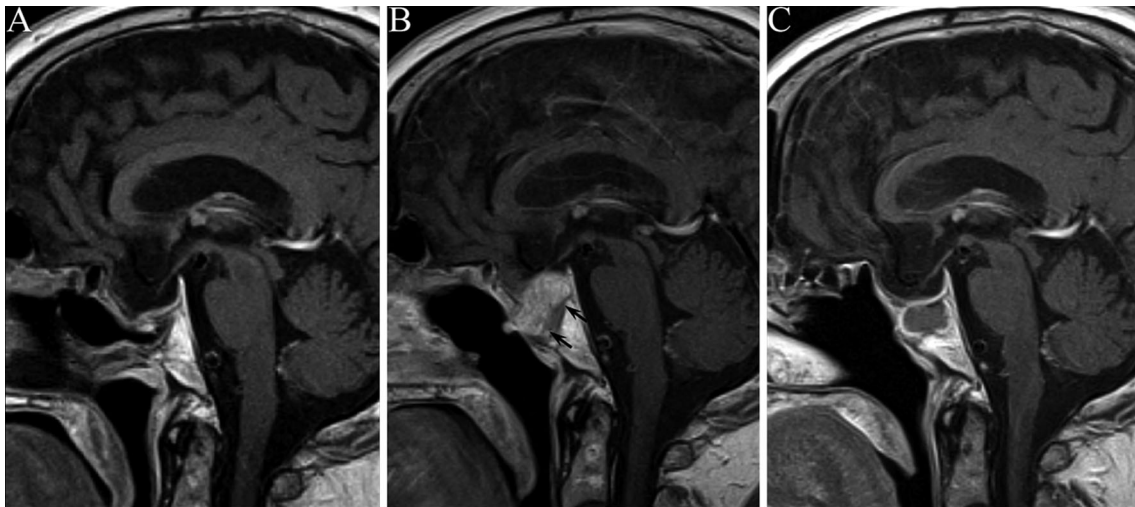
MRI of Patient #4 showing evolution of pituitary adenoma volume: a after latest surgery (1,034 mm³), b before TMZ (8,887 mm³; arrows indicate the contrast enhancing mass appeared in the pituitary sella); and c after TMZ (3,224 mm³)
